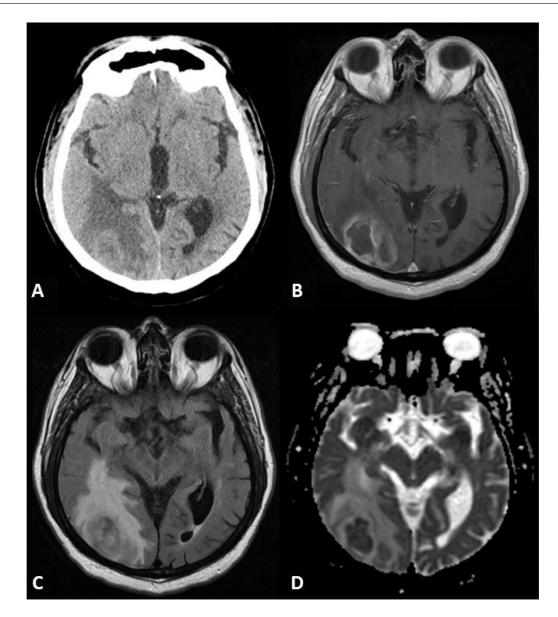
(A–D) – Representative radiographic imaging. (A) Axial noncontrast CT shows a hyperdense ring lesion in the right occipital lobe surrounded by prominent edema. (B–D) Axial MRI images of the lesion. (B) Contrast-enhanced T1 weighted sequence shows a 4-cm ring-enhancing mass in the right occipital lobe. (C) FLAIR sequence displays prominent hyperintense edema surrounding the mass. (D) Apparent diffusion coefficient (ADC) map derived from diffusion weighted imaging displays hypointense signal in the central portion of the mass indicating low diffusivity, a finding that may correspond with necrotic material or purulence. The imaging-based differential diagnosis includes glioblastoma IDH-wild type, metastasis, abscess, and lymphoma. Ring enhancement in lymphoma typically occurs in immunocompromised patients.
